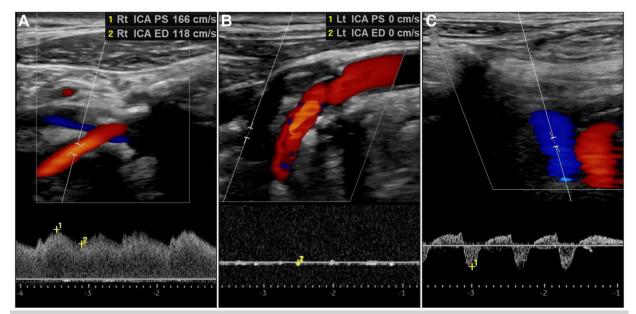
Preoperative carotid ultrasound showing dampened waveforms in the right internal carotid artery (ICA) and elevated velocities in the proximal ICA, consistent with 50% to 60% stenosis (A), absent flow in the left ICA (B), and bidirectional flow in the right vertebral artery (VA; C).
